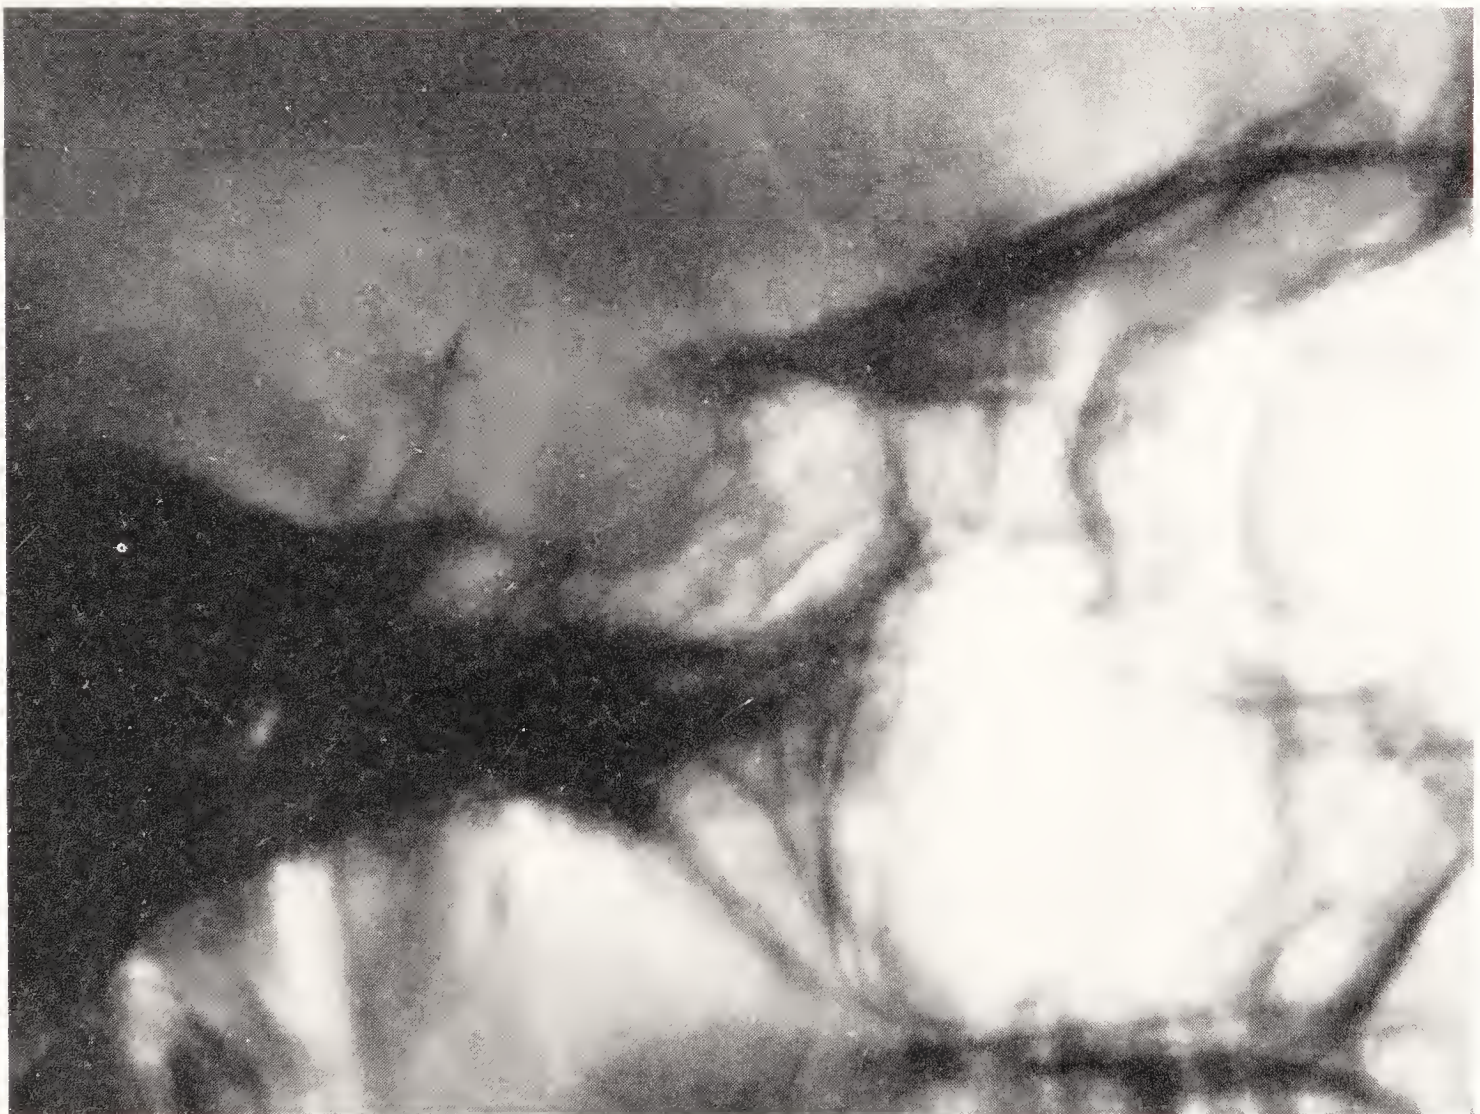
Portion of cranial X-ray (nat. size) disclosing unsuspected enlargement of sella characteristic of adenoma.
